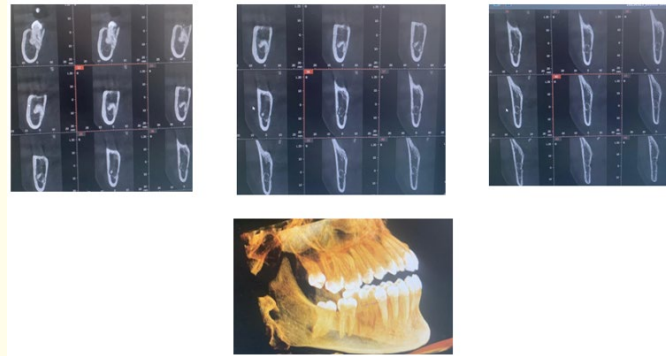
In CBCT, the NAI appears to be inter-radicular with no loss of cortication and snaking through tooth roots.
